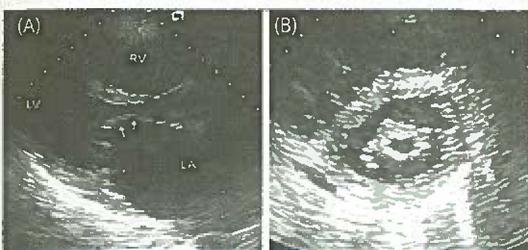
(A) Echocardiography of Mitral Stenosis with restricted motion of the anterior mitral leaflet resulting in diastolic doming (arrows) and a 'hockey stick' appearance (parasternal long axis view). (B) Echocardiography of Mitral Stenosis in parasternal short axis view showing a 'fish-mouth' appearance.
